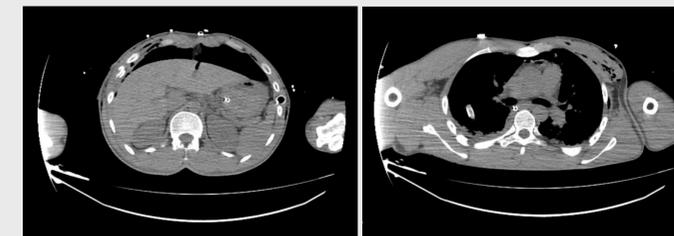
CT scan showing rib fractures with no extensive lung contusions.
